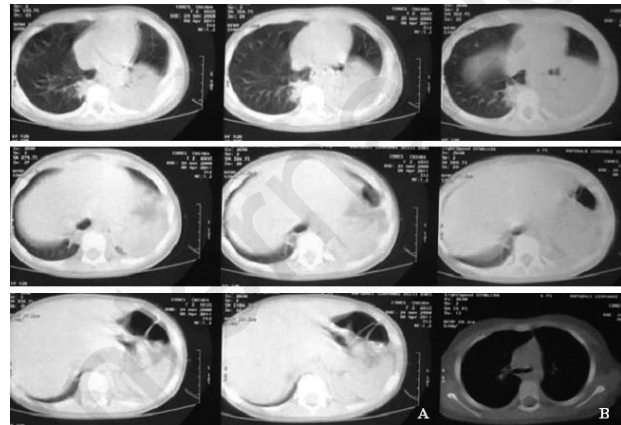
CT before (A) and after (B) VATS in a left meta pneumonic effusion at the second stage.
